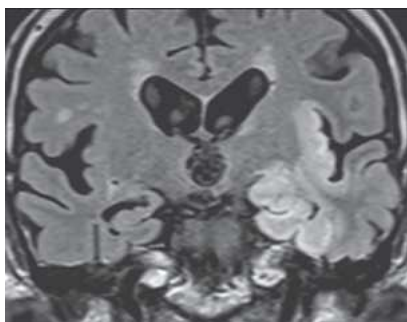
Herpes encephalitis. Coronal FLAIR MRI in a patient with acute herpes encephalitis shows increased T2 signal within the inferior and medial left temporal lobe. (Reproduced with permission from Ropper AH et al. *Adams & Victor's Principles of Neurology*, 10th ed. New York: McGraw-Hill, 2014, Fig. 33-1A.)
